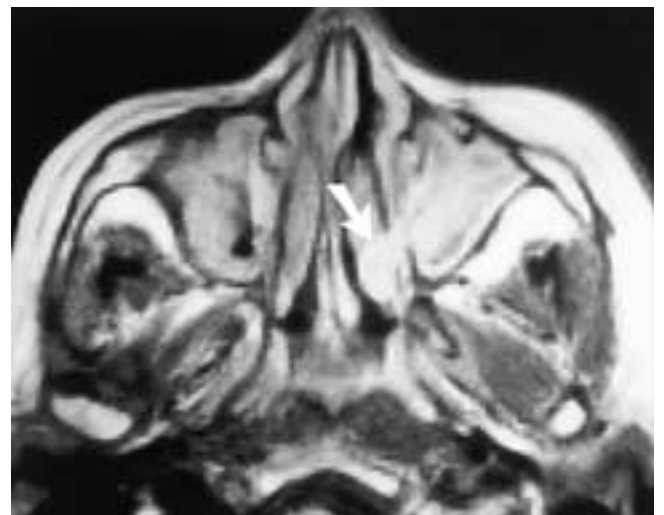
Axial proton density MR image shows inflammatory changes in both maxillary sinuses. On the left side, a polypoid mass fills the left maxillary sinus and extends into the nasal fossa (*arrow*). This patient had an antrochoanal polyp.
